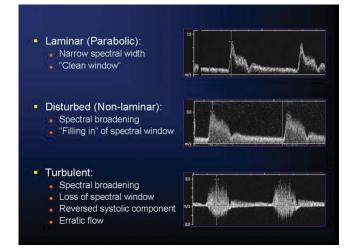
Flow profile characteristics as seen on Doppler waveforms of laminar, non-laminar, and turbulent flows^{1,2,3,5}.
